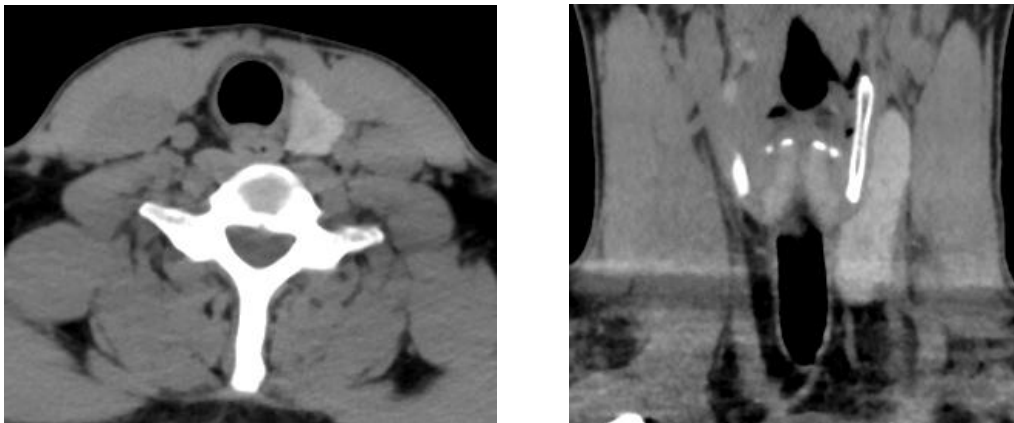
Non-contrast computed tomography scan axial and coronal section of lower neck showing normal left thyroid lobe, absent right thyroid lobe and isthmus.
